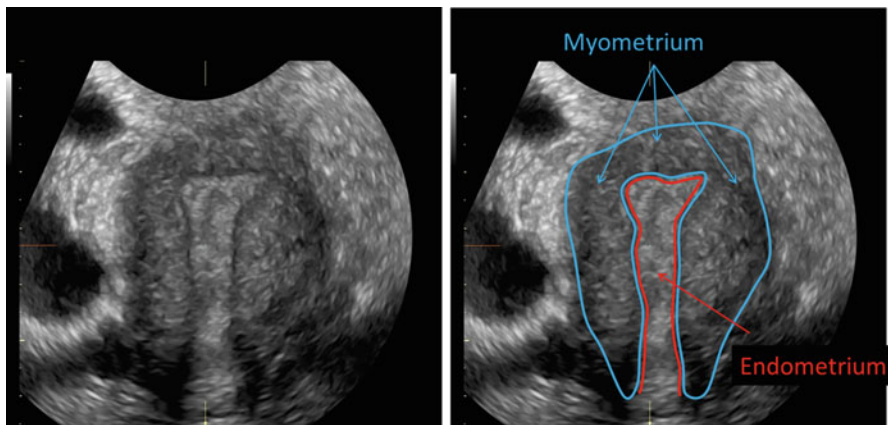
Three-dimensional coronal ultrasound image of normal female uterus. The outer uterine myometrium has a hypoechoic appearance and contrasts with the inner hyperechoic appearance of the endometrial cavity and cervical canal
